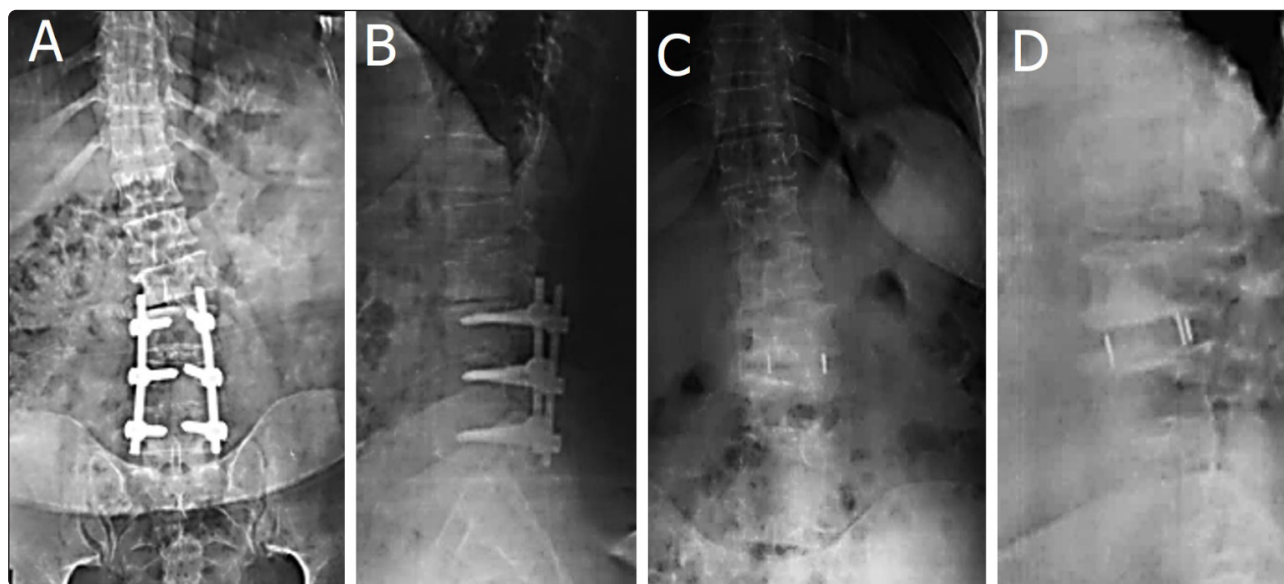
A 45-year-old female presented with back pain and right lower limb pain for 24 months. Back pain is increasing in intensity and aggravated by sitting and standing and relieved by analgesics. Right lower limb pain is found at rest and increased by walking. (A) Preoperative AP L/S X-ray Cobb's angle was 15.5 degrees. (B) Preoperative Lat. L/S X-ray shows SVA: 13 mm, PT: 25 degrees, PI: 53 degrees, SS: 28 degrees, LL: 16 degrees, PI/LL mismatch: 37, and anterior disc height: 6.2 mm. (C) AP L/S X-ray 1-year follow-up Cobb's angle 6 degrees, Sugrimap software A. Cobb's angle in AP X-ray is 15.5 preoperatively. B. Postoperative follow-up in 1-year period with Cobb's angle being 6. (D) Lat. L/S X-ray 1-year follow-up shows SVA: 8 mm, SS: 29 degrees, PT: 24 degrees, LL 21 degrees, anterior disc height: 8.1 mm, and PI/LL mismatch: 32.
